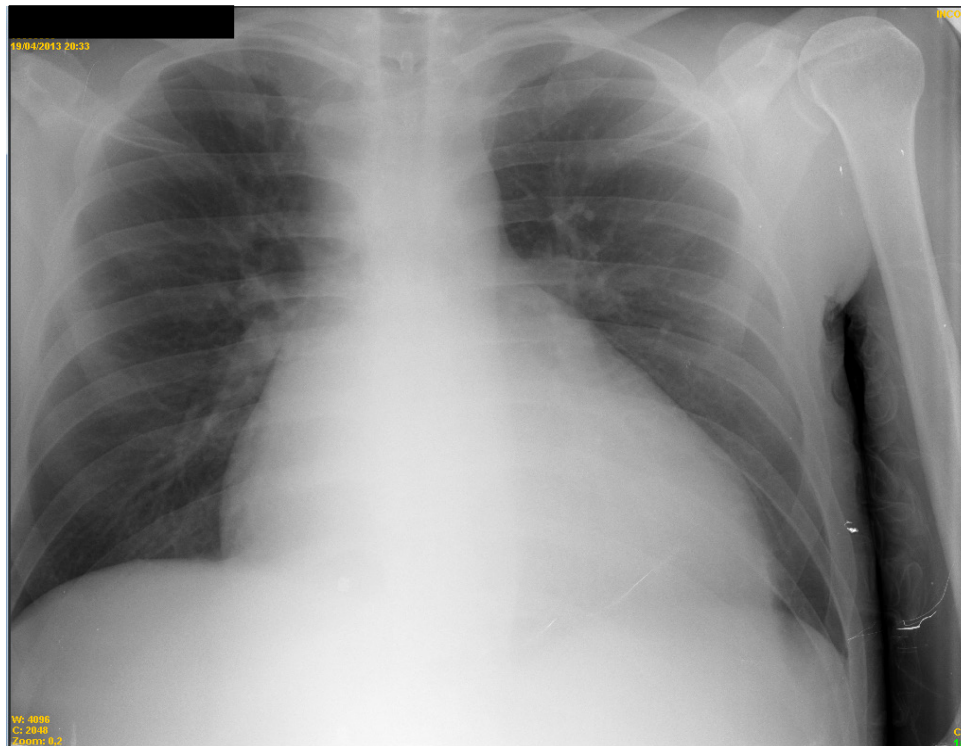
Chest X-ray (posteroanterior). Marked cardiomegaly, rectified middle arch and free pulmonary fields.
